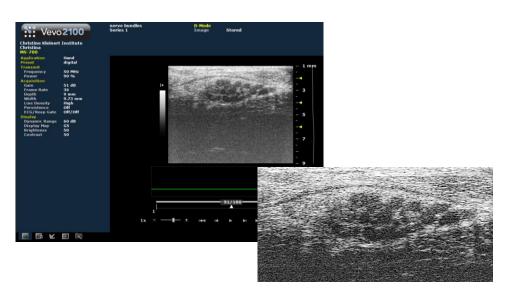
High Resolution Ultrasound imaging of normal Medial nerve using the Vevo 2100. Note the individual nerve bundles within the nerve that can be non-invasively distinguished with respect to size and number
